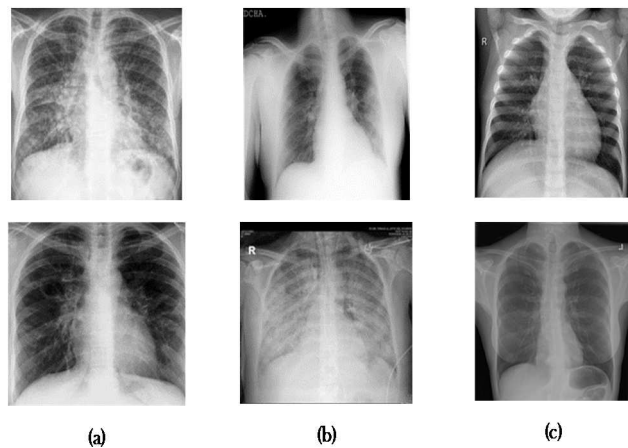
Different classes of chest X-ray images: (a) sarcoidosis-infected, (b) covid-19-infected, (c) normal.
